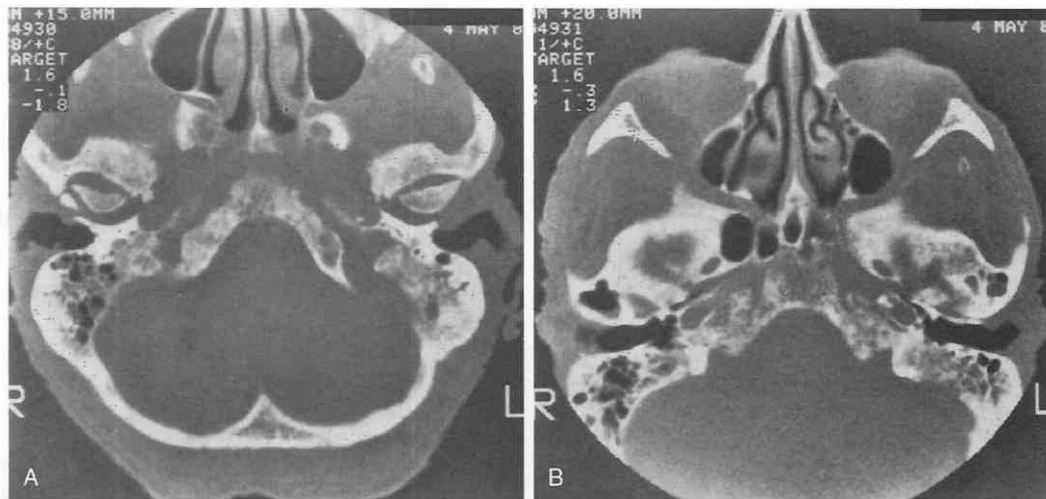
Metastatic prostatic carcinoma in an elderly man with a history of severe headaches, ear pain, and known prostate cancer. A and B, Axial CT scans of the skull base show extensive mixed lytic and blastic metastases involving the clivus and petrous apices. There is moderate destruction of the inferior portions of the petrous bones bilaterally, with patchy opacification of the mastoid air cells.
